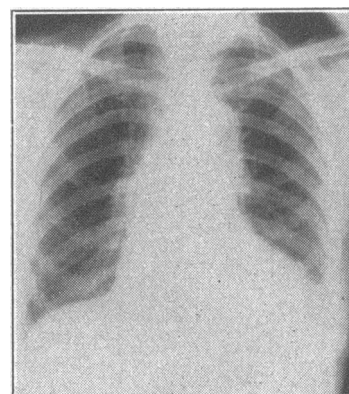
Chest x-ray film of patient shown in Fig. 10 taken at same time; great reduction in heart size.
